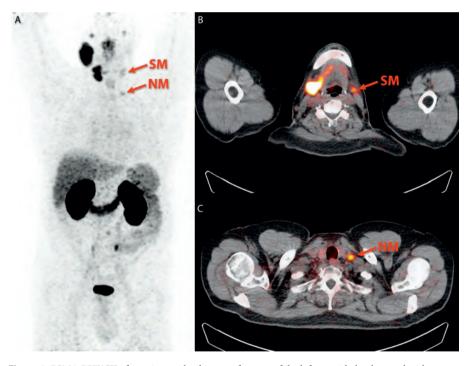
PSMA PET/CT of a patient with a history of cancer of the left parotid gland treated with surgery and radiotherapy, and prostate cancer treated with radiotherapy with current biochemical recurrence. An anterior projection of the body is shown (A), and transverse slices at the level of the neck (B) and upper thoracic outlet (C). The cytologically proven nodal metastasis from prostate cancer in the lower neck (NM) has equivalent uptake as the irradiated submandibular gland (SM) and several normal tissues in the neck (e.g., the glands in the supraglottic larynx). This may lead to confusion and misinterpretation when normal patterns are not adequately recognized.
